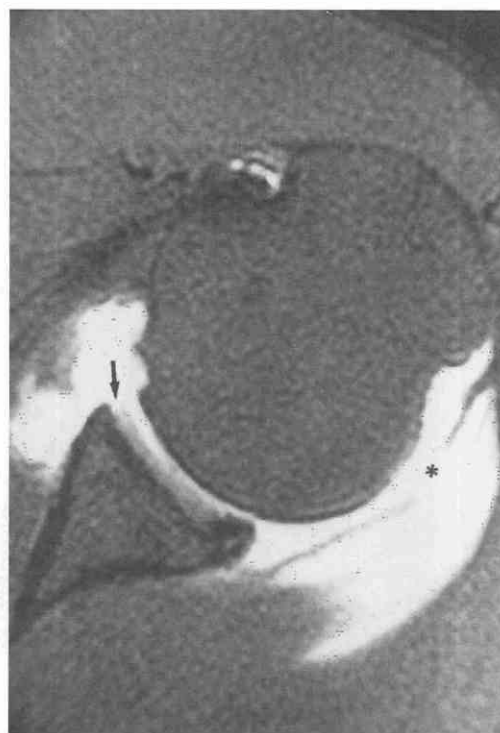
Posterior capsular tear. T1-weighted (TR = 500 msec, TE = 14 msec), fat-saturated, axial MR arthrogram image. A tear in the posterior joint capsule (*asterisk*) allows gadolinium to escape into the adjacent soft tissues. The anterior labrum has been avulsed as well (*arrow*).
